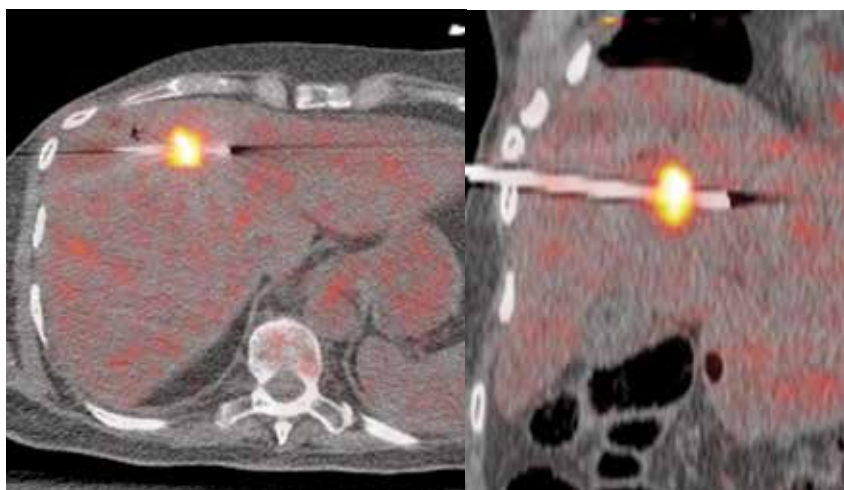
Axial- and coronal-fused PET/CT images acquired with suspended ventilation confirm excellent microwave ablation probe placement through tumor in two planes.
